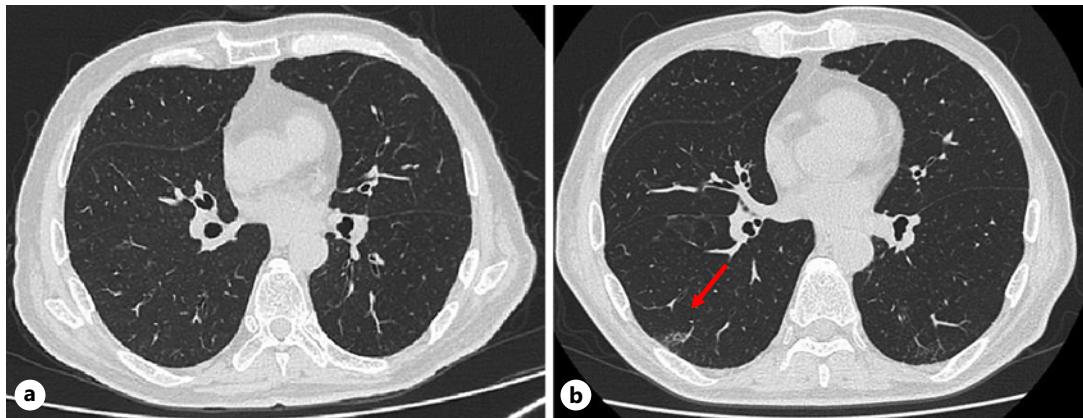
Chest computed tomography (CT) findings of case 1, after 3 months (April 2022) (a), and 5 months (June 2022) (b) of enfortumab vedotin treatment. CT revealed minor ground-glass opacities.
